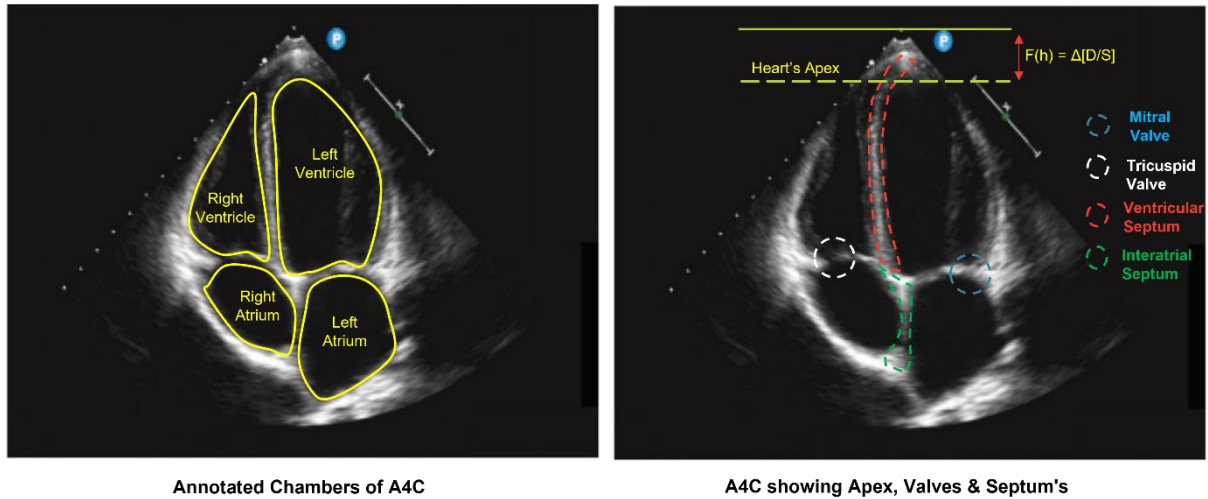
Apical four chamber images with annotation for chamber cavities (atrium, ventricles), Mitral valve, Tricuspid valve, interatrial and interventricular Septum.
